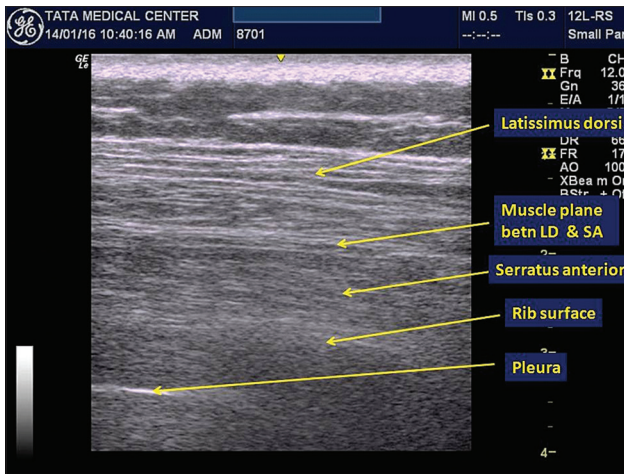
Initial ultrasound scan to note the sonoanatomy
